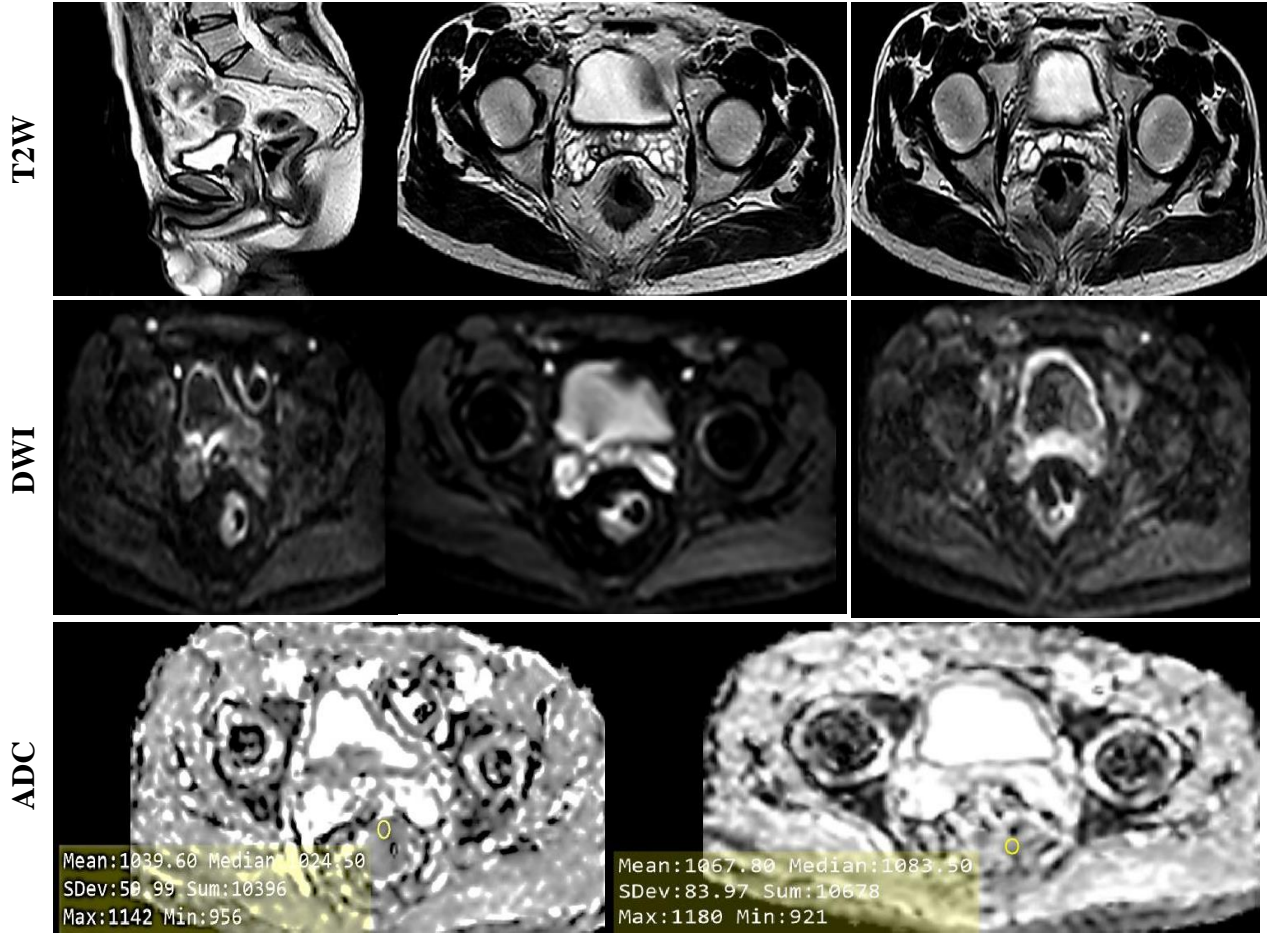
A 66-year old female patient presented with constipation and bleeding per rectum; Colonoscopy and biopsy revealed well-differentiated adenocarcinoma. Pretreatment MRI pelvis revealed irregular mucinous mass in upper and mid rectum and extending to recto-sigmoid; MRF invasion (T3); 6 mm beyond Musculosa Propria (T3c); CRM positive (< 1 mm); preserved fat plane between the mass & posterior uterine margin; no LNs involvement (N0); $ADC = 1.152 \times 10^{-3} \text{ mm}^2/\text{s}$ (consistent with well-differentiated tumor) → [T3c N0]. Post-treatment MRI pelvis (4 months later) revealed cancer in upper & mid rectum; decrease in size; MRF invasion (T3), 4.4 mm beyond Musculosa Propria (T3b); CRM negative 7.8 mm); no LNs involvement (N0); $ADC = 1.224 \times 10^{-3} \text{ mm}^2/\text{s}$ (consistent with regressive course); [the mean ADC equation: $1.224 - 1.152 = 0.72 \times 10^{-3} \text{ mm}^2/\text{s}$] → [T3b N0]. Post-treatment MRI pelvis (6 months later) revealed no recurrent masses and pathology report revealed no residual tumor, dense active inflammation and ulceration, free resection margins, free LNs (complete therapy response)
